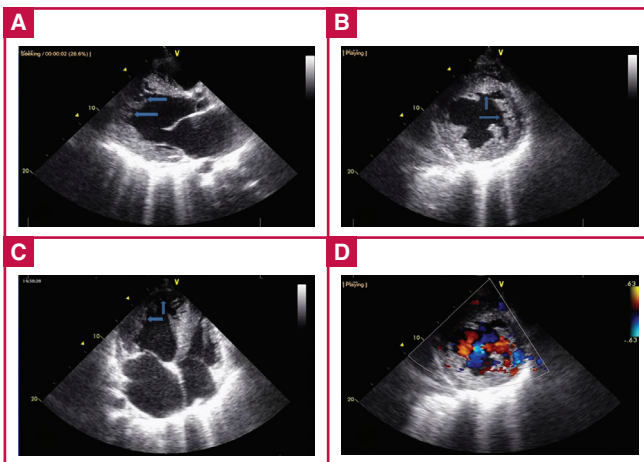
Transthoracic two-dimensional parasternal long-axis (A), parasternal short-axis (B), and apical four-chamber (C) images show isolated non-compaction of the left ventricle with multiple trabeculae and inter-trabecular recesses in the lateral, apical, anterior and mid-septal areas. Appearance of blood flow from the ventricular cavity to these deep trabeculae was detected by colour Doppler imaging (D).
